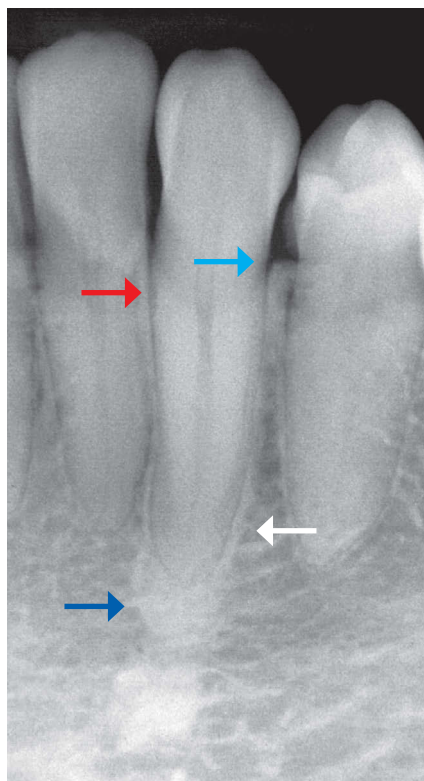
Occlusal trauma with lamina dura thickening (white arrow), broadening of the periodontal space (red arrows), with periodontal and periapical bone density increase (light blue arrow) and V-shaped vertical bone loss (green arrow).
